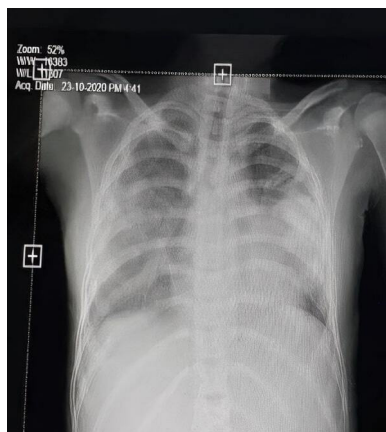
Chest X-ray anteroposterior view (day 1).
